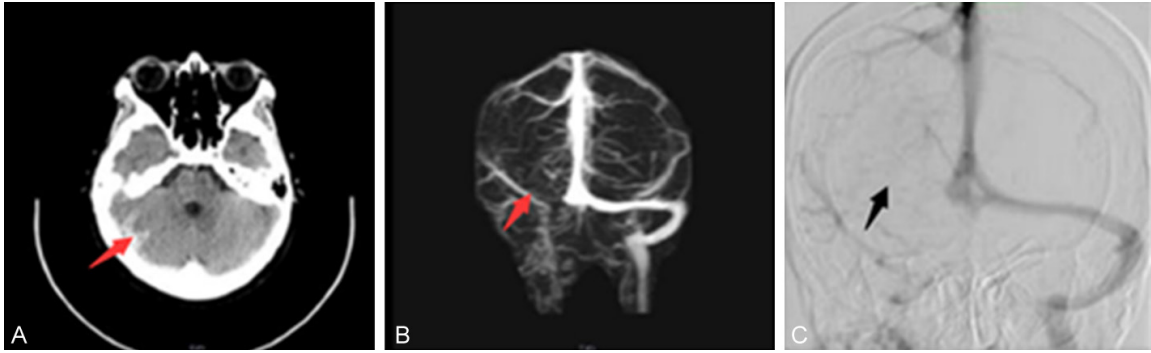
A 24-year-old female patient was admitted to the hospital with the main complaint of a persistent headache lasting for two days. She had a history of oral contraceptive use two months prior to admission. A. Plain head computed tomography (CT) scan showed increased density in the right transverse sinus, presenting the classic “delta sign” (δ sign; see red arrow). B. Cranial magnetic resonance venography (MRV) demonstrated non-visualization of the right transverse sinus and sigmoid sinus (see red arrow). C. Digital subtraction angiography (DSA) further confirmed the absence of visualization of the right transverse and sigmoid sinuses, accompanied by dilation of cortical veins in the right cerebral hemisphere (see black arrow).
